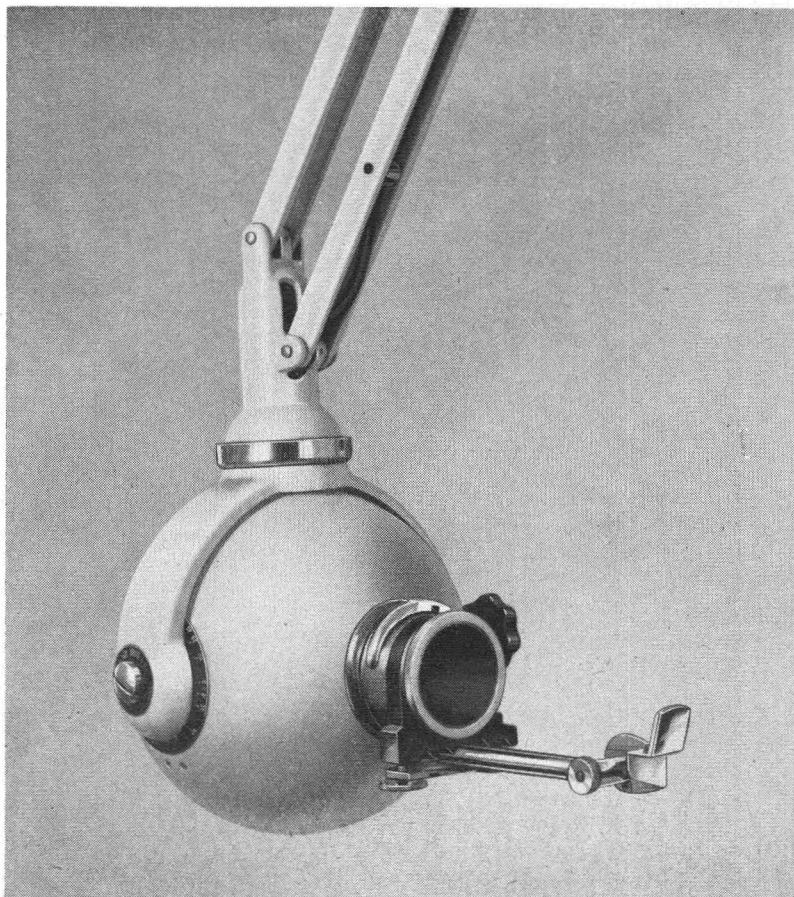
The apparatus for intra-oral radiography.
